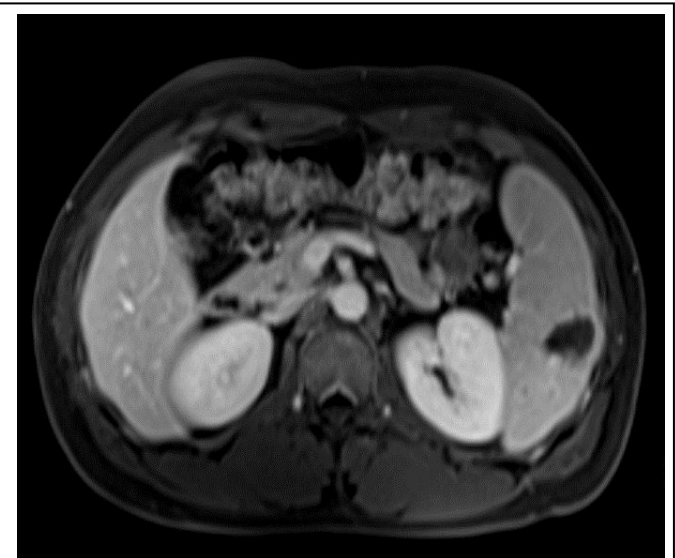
Abdominal MRI T1 showing hypo-intense splenic lesion.
